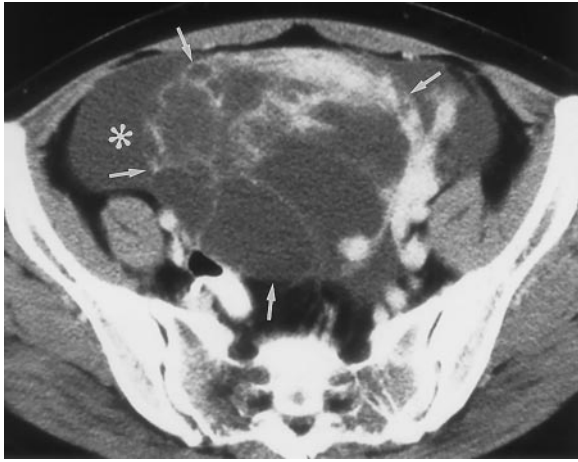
Endodermal sinus tumor in a 29-year-old woman. Contrast-enhanced CT scan shows a large, complex pelvic mass with solid and cystic components (arrows). Associated ascites is also seen (*). The patient had an elevated serum α -fetoprotein level of 58,000 IU/mL (normal range, 0–15 IU/mL).
